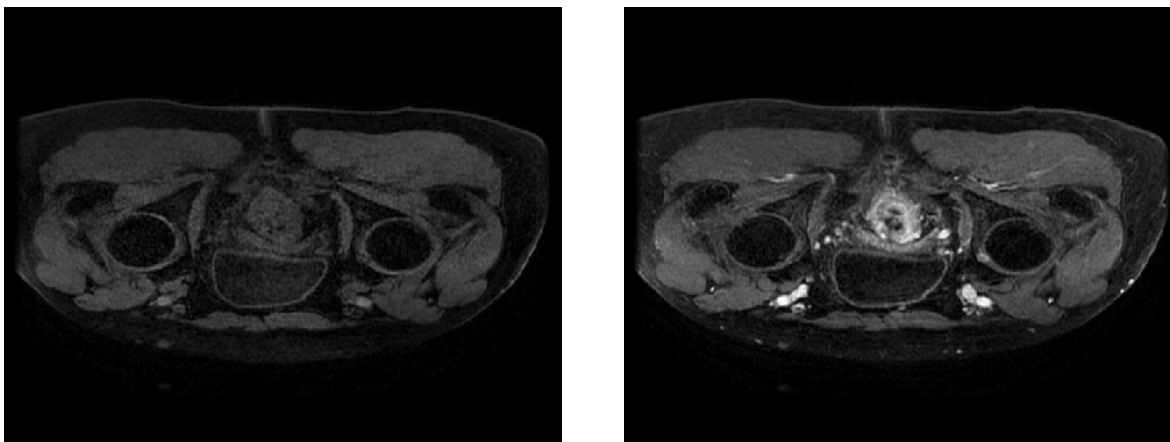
Central slices from the image volume acquired before injection of the CA (left) and the image taken 2 minutes after injection of CA (right) during a DCE-MRI scan of a colorectal tumour. The brighter portions of the right frame indicate the presence of the contrast agent.
